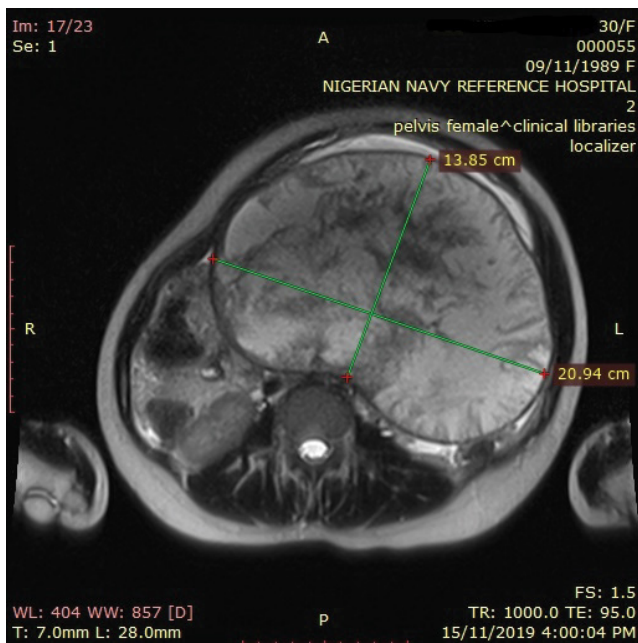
Axial Non-contrast T1W Magnetic Resonance Image showing grossly enlarged uterine mass with heterogeneously intense appearance.
